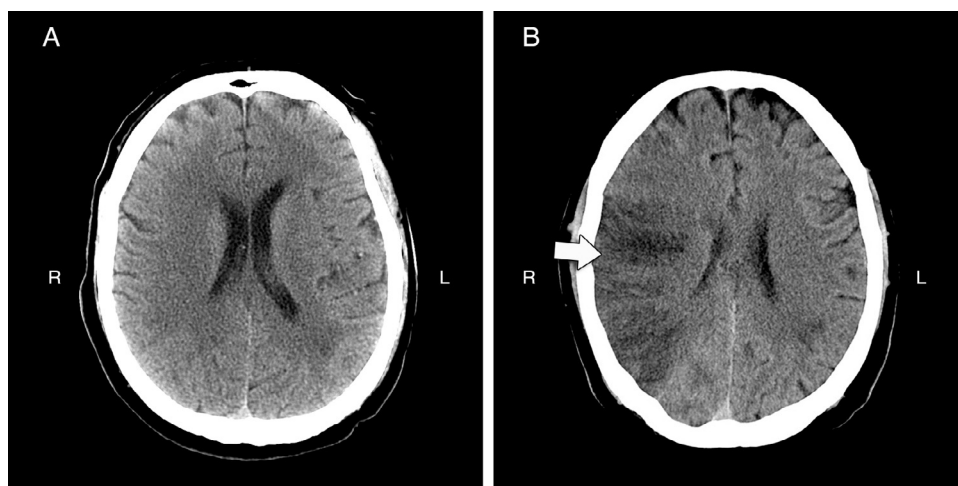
Initial (on day 0, panel A) and follow-up (on day 3, panel B) cranial computed tomography (CT) images. Arrow indicates signs of ischemic brain infarction in the right middle cerebral artery blood supply zone on the repeated brain CT. R, right; L, left.
